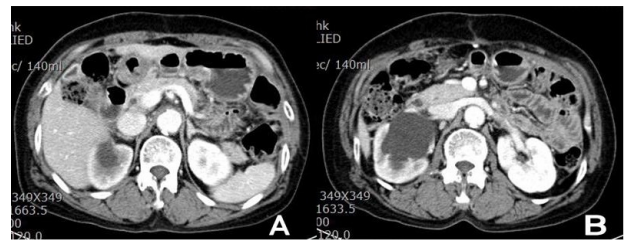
(A) After 9 cycles of chemotherapy, abdominal CT scans showed improving process with decreased ascites. (B) There are also hydronephrosis and hydroureter at the right kidney and ureter. CT: computed tomography.
